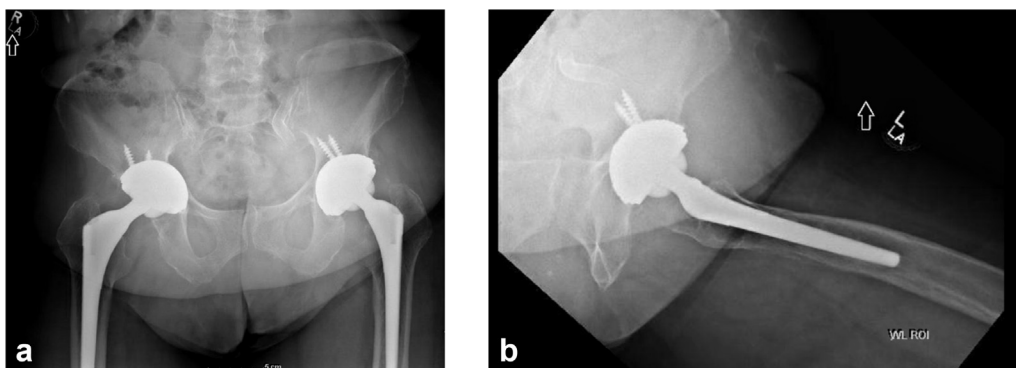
(a) Anterior-posterior pelvis radiograph demonstrating bilateral total hip arthroplasty with no hardware complications. Of note, on this single view, there is no obviously malpositioned hardware in the left hip or soft tissue masses. (b) Frog-leg lateral view of the left hip, again with no hardware complications or soft tissue masses.
